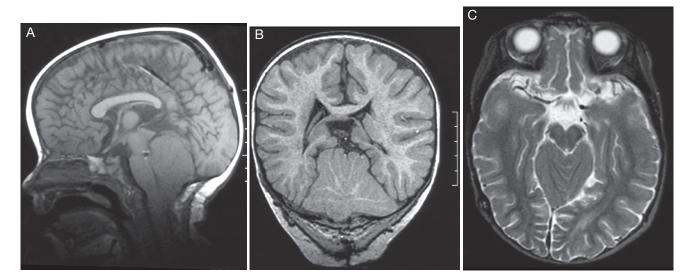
Magnetic Resonance Imaging in Chiari Type II malformation in a 16-Month-Old Infant After Repair of a Myelomeningocele.
